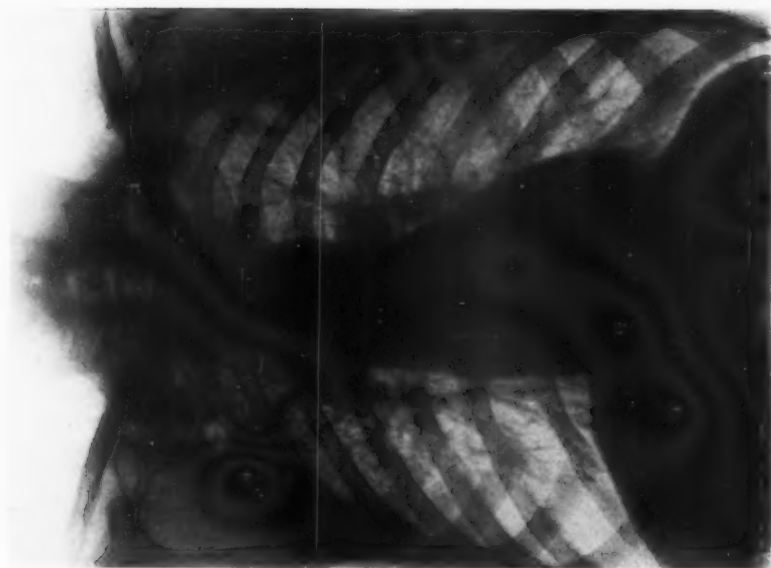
An ordinary radiograph.
